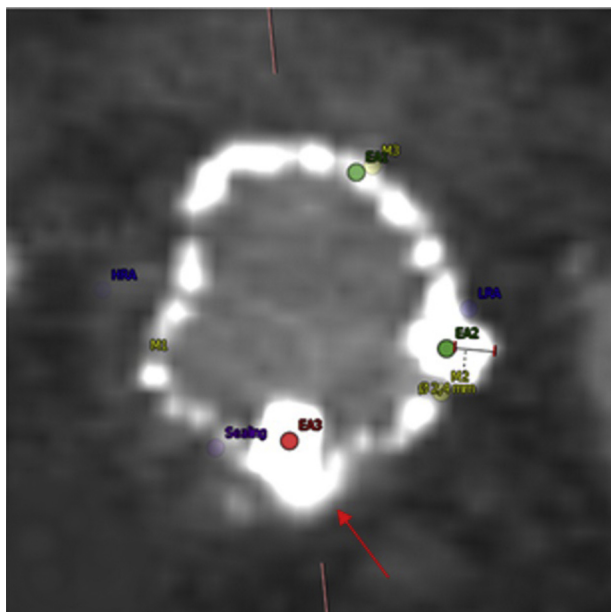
Perpendicular postoperative computed tomography (CT) image after implantation of an EndoAnchor in a highly calcified region. The figure shows a nonpenetrating EndoAnchor implant at the calcium load (red arrow). The blue labels represent the highest renal artery (HRA) and lowest renal artery (LRA). The yellow markers represent the markers of the endograft, whereas the purple marker points at the end of the proximal neck where sealing ends. Two green labels point at good penetrating EndoAnchor implants.
